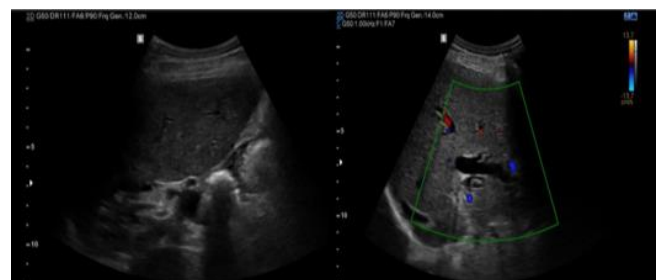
Ultrasound of the abdomen in axial sections shows a large echogenic calculus with posterior acoustic shadowing in the common bile duct with severe dilatation of the proximal common bile duct and the intrahepatic biliary radicles.
